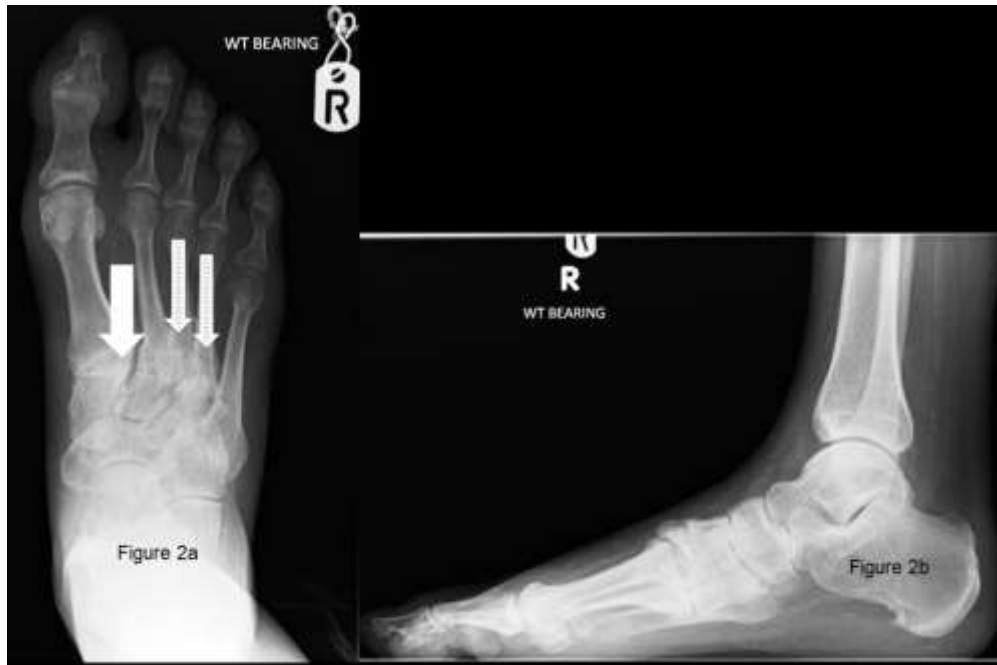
Right foot AP and lateral radiograph demonstrating erosive arthropathic changes of the tarsometatarsal joints – in particular the first– with reduction in joint space and sclerosis(solid arrow). In addition, there are ununited fractures at the base of the third and fourth metatarsals (striped arrows).”
